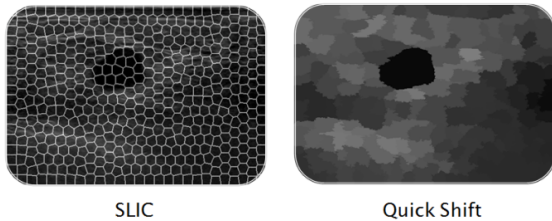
Comparison of superpixel over-segmentation algorithms on an ultrasound image. Left: SLIC, with regularised superpixel sizes and shapes. Right: Quick Shift, with the mean of each superpixel shown.
